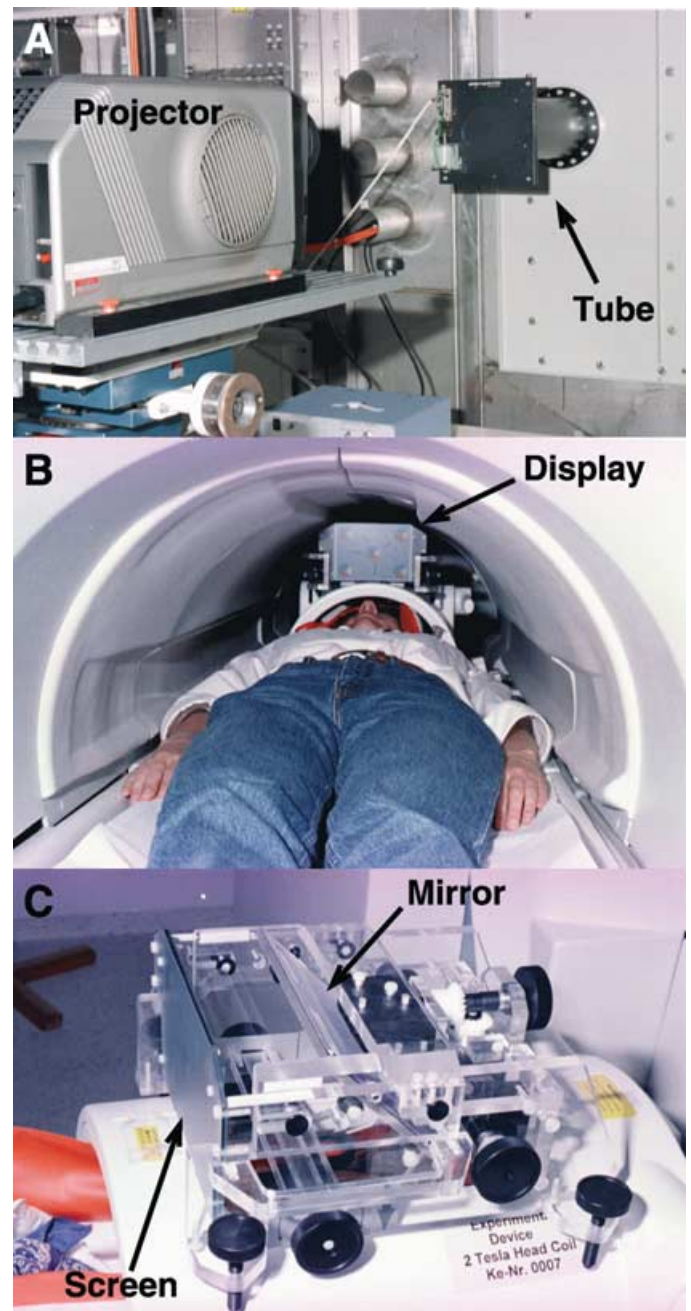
Experimental setup for the presentation of visual stimuli. (A) Stimuli were generated by a computer and fed into a modified video projector. They were projected from outside the magnet room through a radiofrequency-shielded tube into (B) the magnet bore onto (C) a head-mounted translucent display atop the MRI headcoil. The subjects viewed the projected stimulus through two oculars via a 45° mirror. The setup covered $\pm 20^\circ \times \pm 15^\circ$ of the subjects' visual field.
